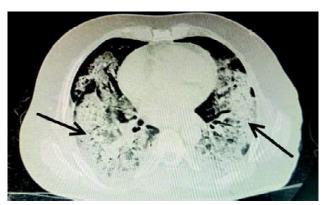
CT Massive multi-lobar consolidation (black arrows) with air bronchoaram.
